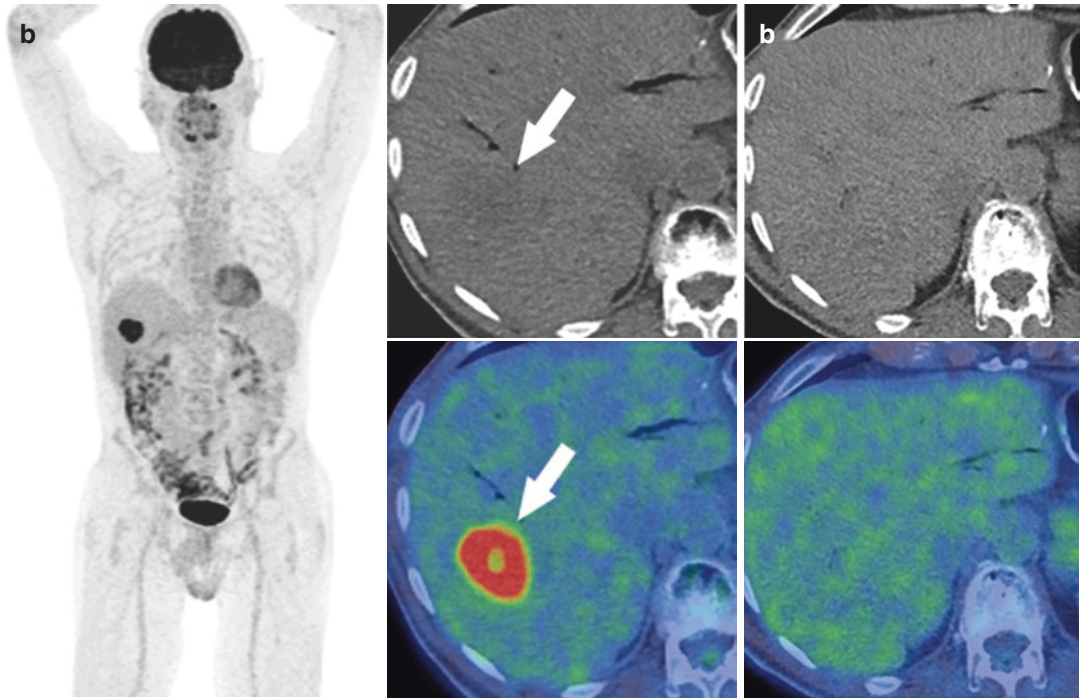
Disease progression: (a) Staging FDG PET/CT shows tracer avid soft-tissue mass involving head and neck of pancreas with SUVmax 15 (arrow). There is no pathological lesion in the liver. (b) Post chemoradiation
